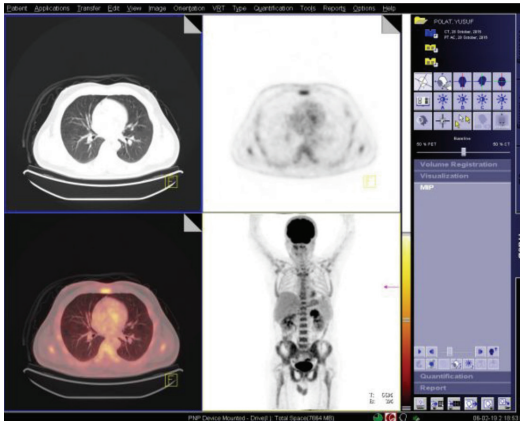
At the result of PET/CT scan, F-18 FDG uptake pattern of lesion in the left breast
